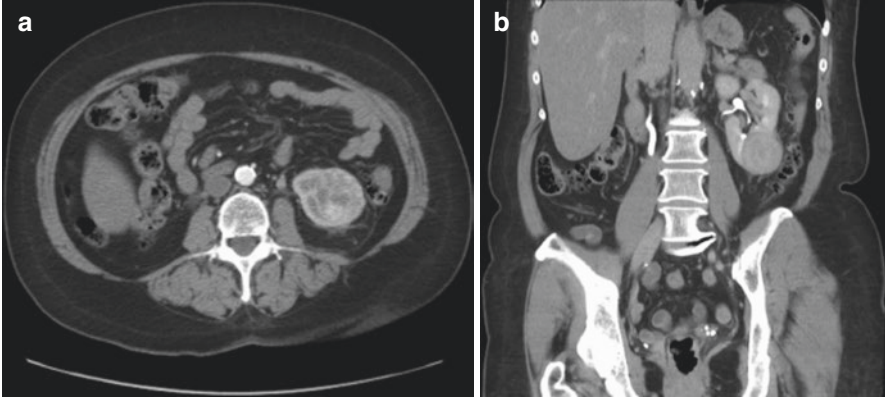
(a) axial and (b) coronal computed tomography images of a “moderate-complexity” lesion. R.E.N.A.L. nephrometry score = $2 + 2 + 2 + x + 2 = 8x$
